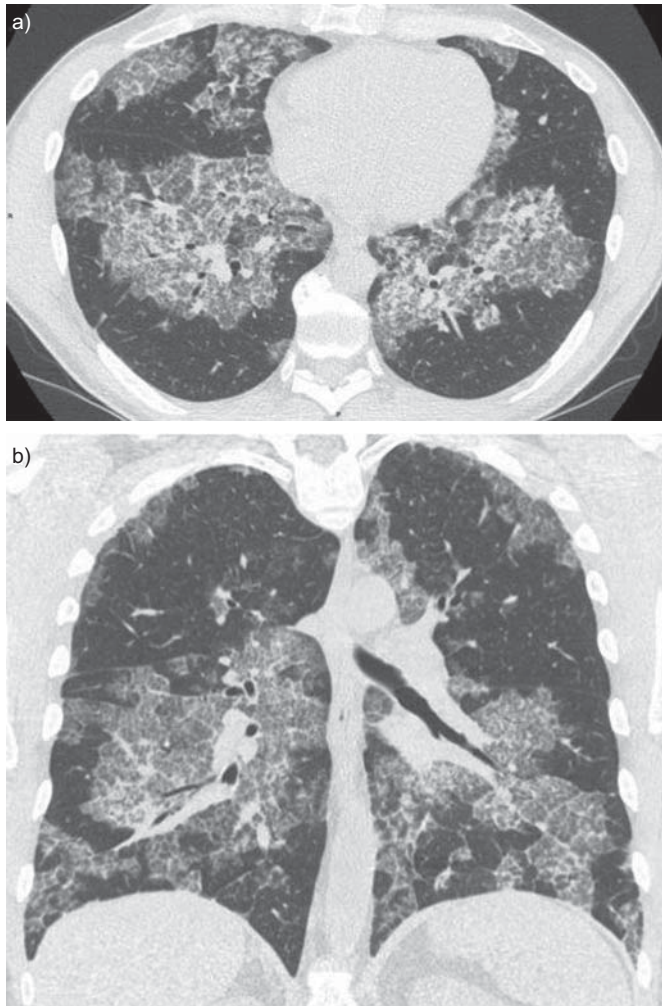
Chest computed tomography scan of a patient with auto-immune pulmonary alveolar proteinosis. Reticulations are superimposed on ground-glass opacities forming a “crazy paving” pattern with a geographic distribution: juxtaposition of healthy and sick zones. a) A horizontal section and b) a coronal section.
